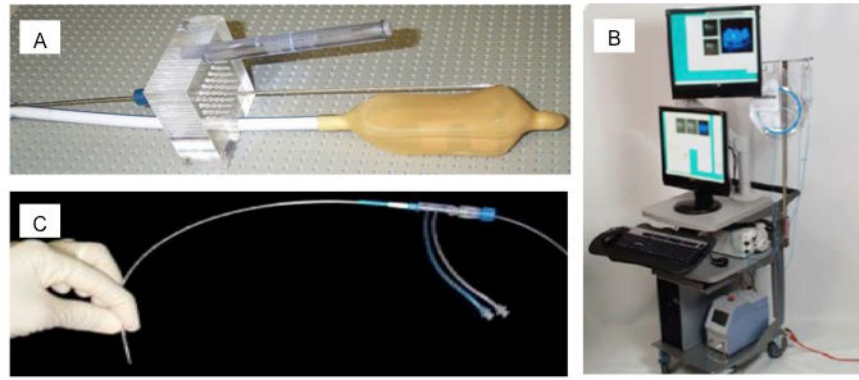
Instruments used for targeting and treating foci of prostate cancer by MRI-guided focal laser ablation. (A) An MR-compatible transperineal template is fixed to an endorectal coil. (B) A high-quality T2-weighted image of the prostate is acquired and loaded into the software (Visualase, Inc.) for guiding applicator placement. Titanium trocars and guide catheters are placed through the appropriate grid hole on the transperineal template as determined by the planning software. (C) When the laser tip is situated in the desired location, laser treatment is initiated. MRI, magnetic resonance imaging; MR, magnetic resonance.
